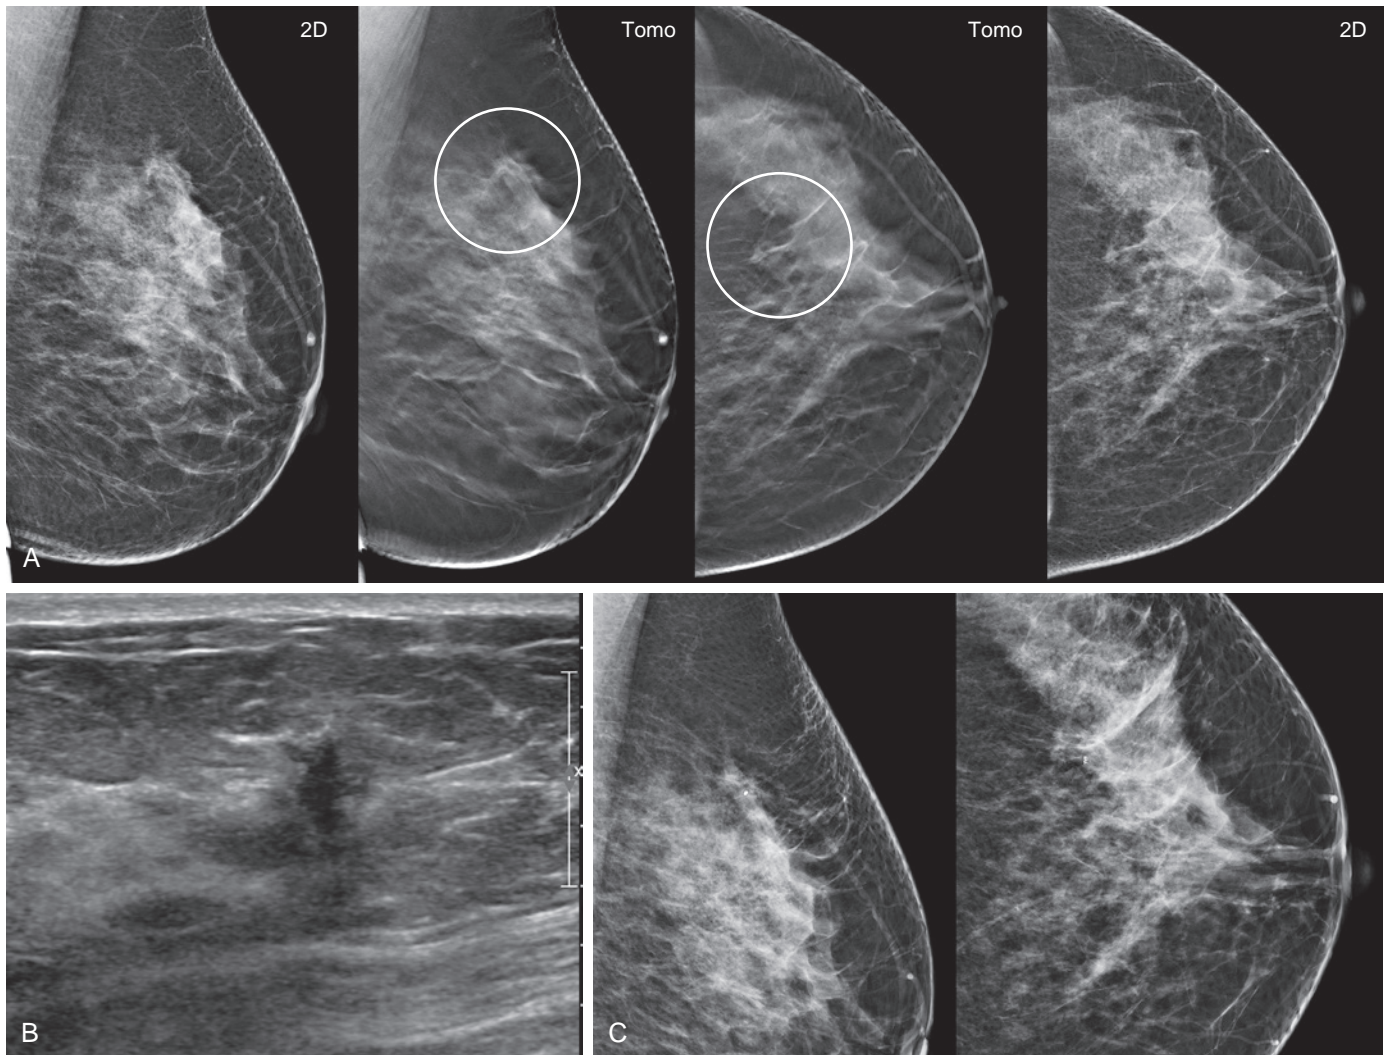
Straightening of glandular tissue and Cooper's ligaments may be the best clue to detect a subtle malignancy. Screening mammogram in a 38-year-old woman with a strong family history of breast cancer. (A) A subtle architectural distortion is present in the left upper central breast (*circles*), seen only on tomosynthesis. Note that straightening of the glandular tissue and Cooper's ligaments is the best clue that a true lesion exists. (B) Targeted ultrasound reveals a corresponding irregular hypoechoic mass with an antiparallel orientation. Ultrasound-guided CNB revealed an infiltrating ductal cancer, grade 2, ER/PR/Her(-). (C) Post-biopsy 2D mammogram shows the biopsy marker in the correct location.
